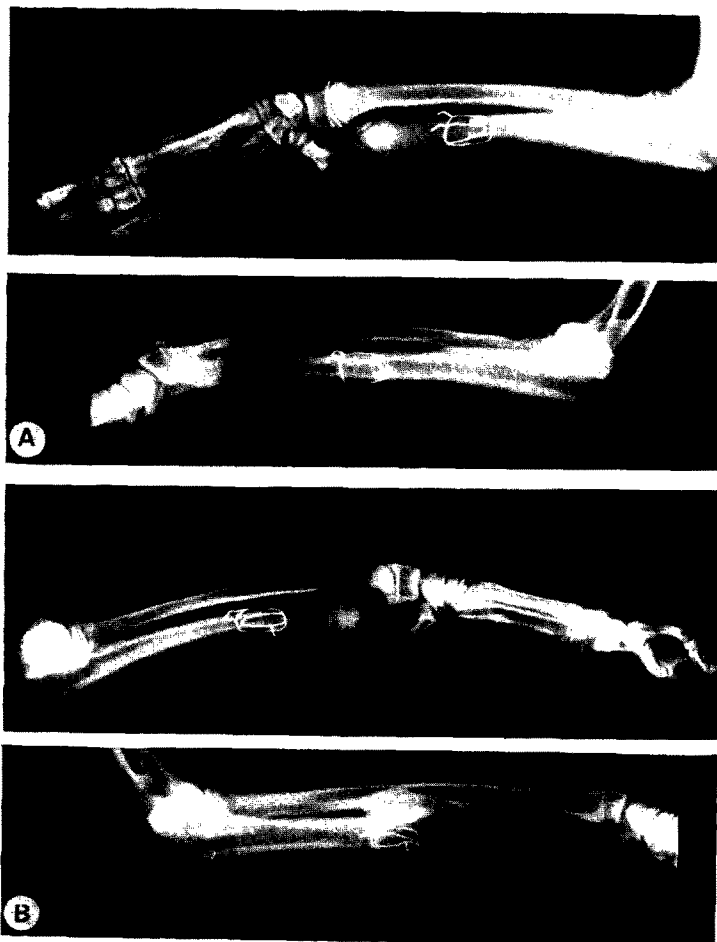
Heterotopic epiphyseal transfer: X-rays at operation (above) and at 6 months (below).
